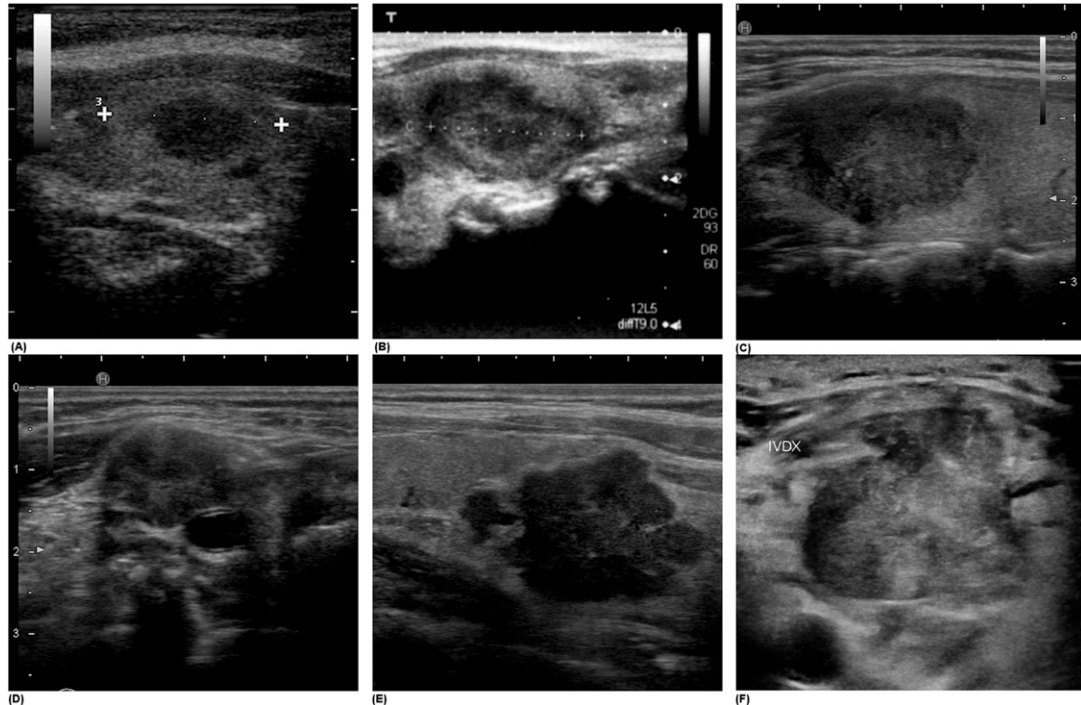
Ultrasonographic images of the metastatic lesions (A) renal cell carcinoma metastasis to the thyroid; (B) thyroid metastasis from lung adenocarcinoma; (C) thyroid metastasis and (D) level 2 cervical lymph node metastasis from breast cancer; (E) thyroid metastasis from esophageal cancer; and (F) thyroid metastasis from lung cancer. Detailed descriptions and US classifications are provided in [Table 1](#).
